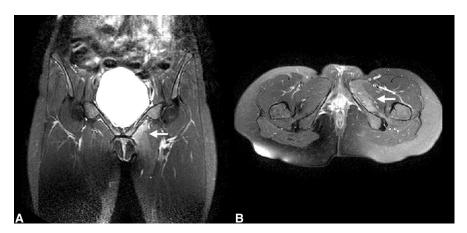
Coronal (A) and axial (B) fatsuppressed T2-weighted MRIs of the upper thigh showing increased signal within the adductor brevis and adductor magnus on the left (arrows). Atrophy of these muscles is also evident.
